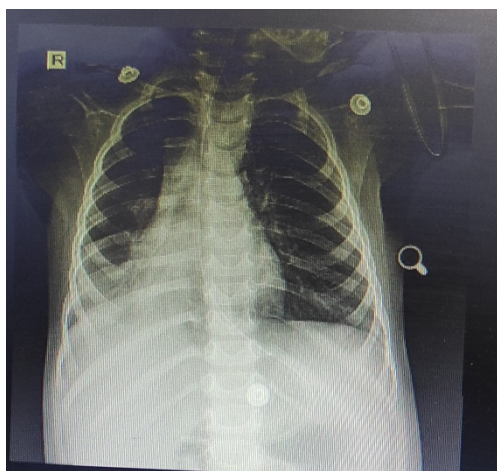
Pre operative X-ray showing bilateral infiltrates in the lower zone
